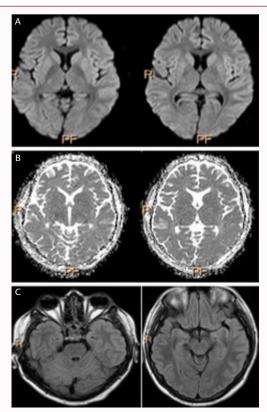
MRI Brain showing complete resolution of lesions (DWI, ADC & FI AIR)
